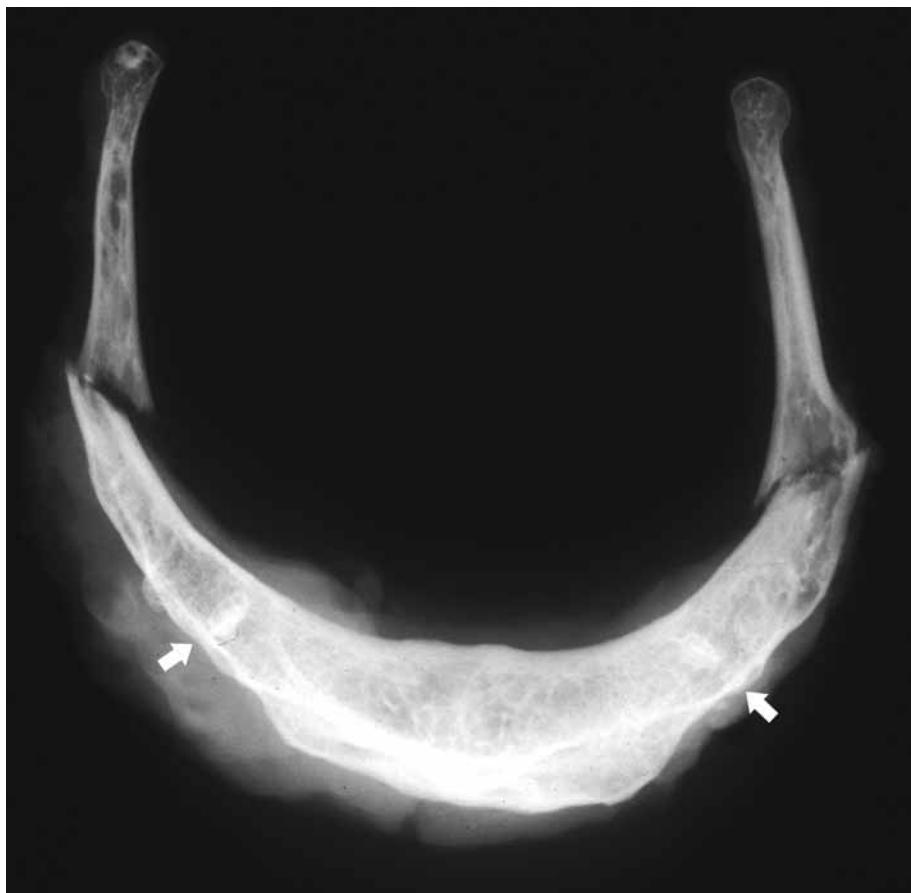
Suicidal hanging; prolonged suspension. Radiograph of hyoid bone. Bilateral fractures of greater horns. Note bilateral fusion of body and greater horns (arrows).
